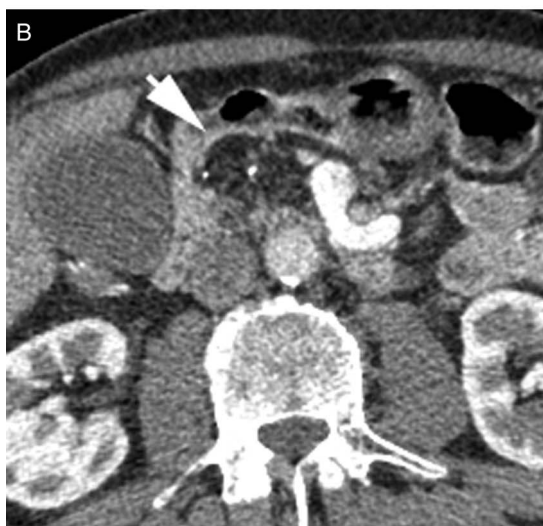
(A) CT contrast-enhanced of the abdomen and pelvis showing a decrease in colonic wall thickening (arrow) with resolution of nodes after corticosteroid therapy. (B) CT contrast-enhanced of the abdomen and pelvis showing complete fatty replacement of the pancreatic parenchyma (arrow) with a few flecks of calcification after corticosteroid therapy.
